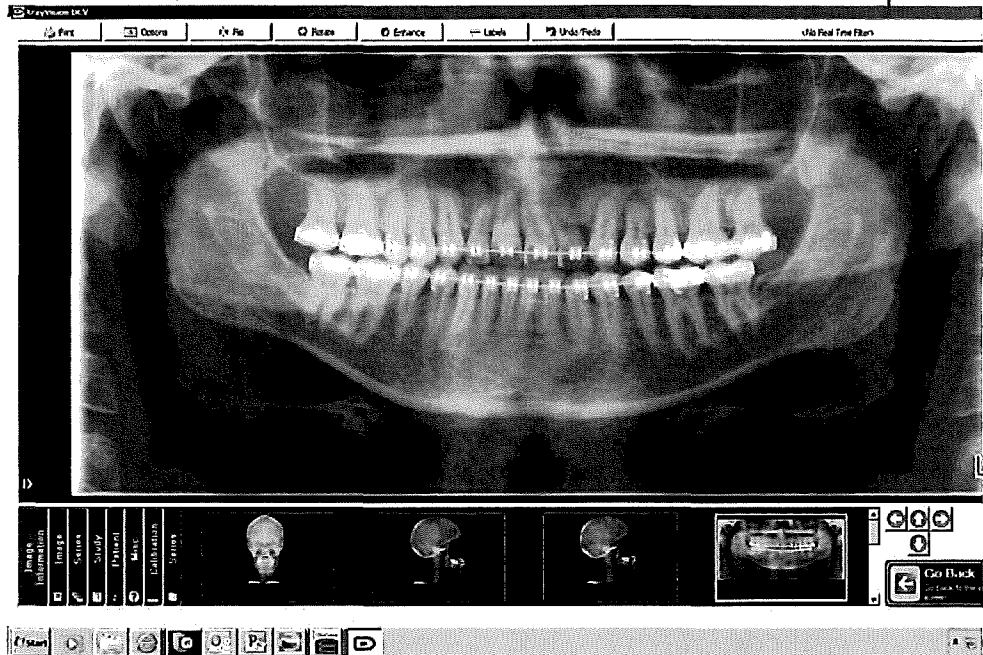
Comment: Questionable periapical region over #12
